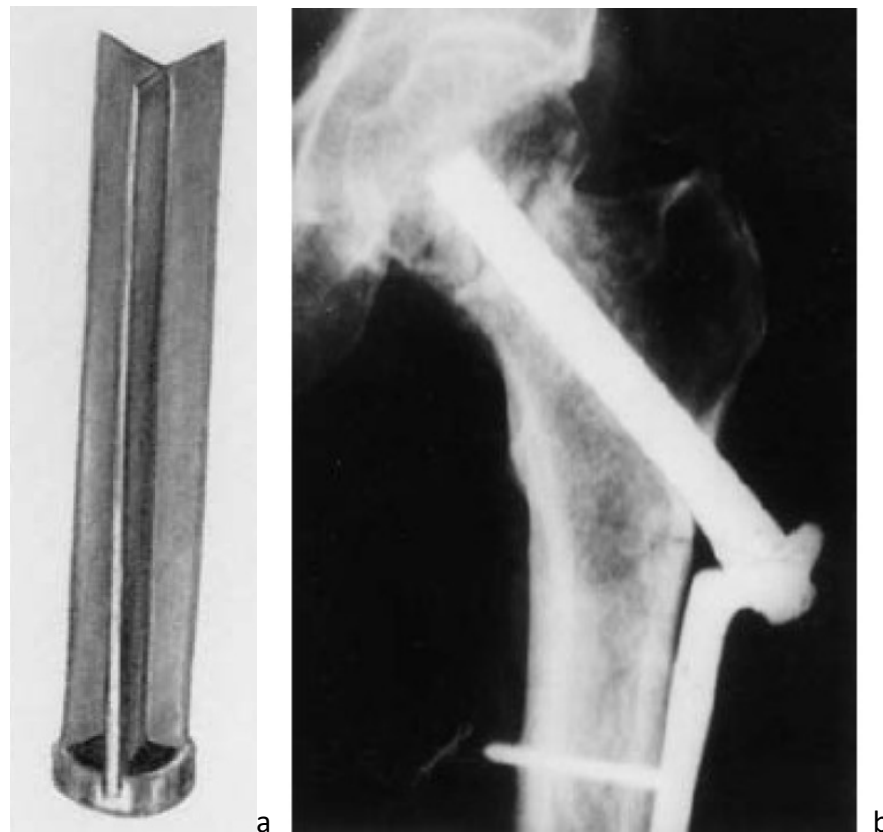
Three flanged nail device similar to that introduced by Smith-Petersen (a) and radiograph of implanted nail with endplate inserted into lateral cortex as in the Thornton nail (b). Reproduced with permission from Springer (licence number: 4450941137684); [9].
